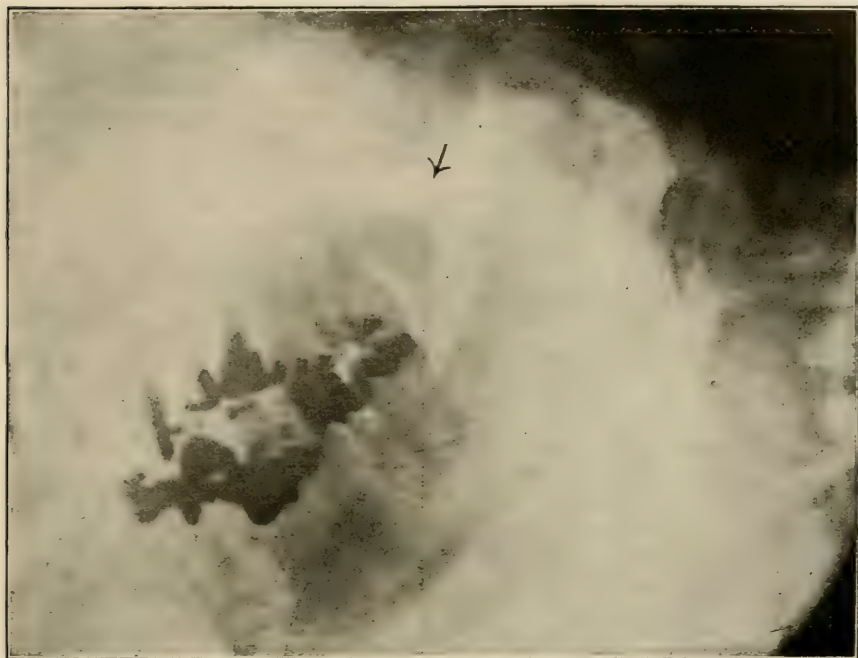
The arrow points to an impacted upper, third molar, the cause of "idiopathic" neuralgia, from which the patient had suffered recurrently for from between twenty-five to thirty years. (Radiograph by A. M. Cole, of Indianapolis.)
